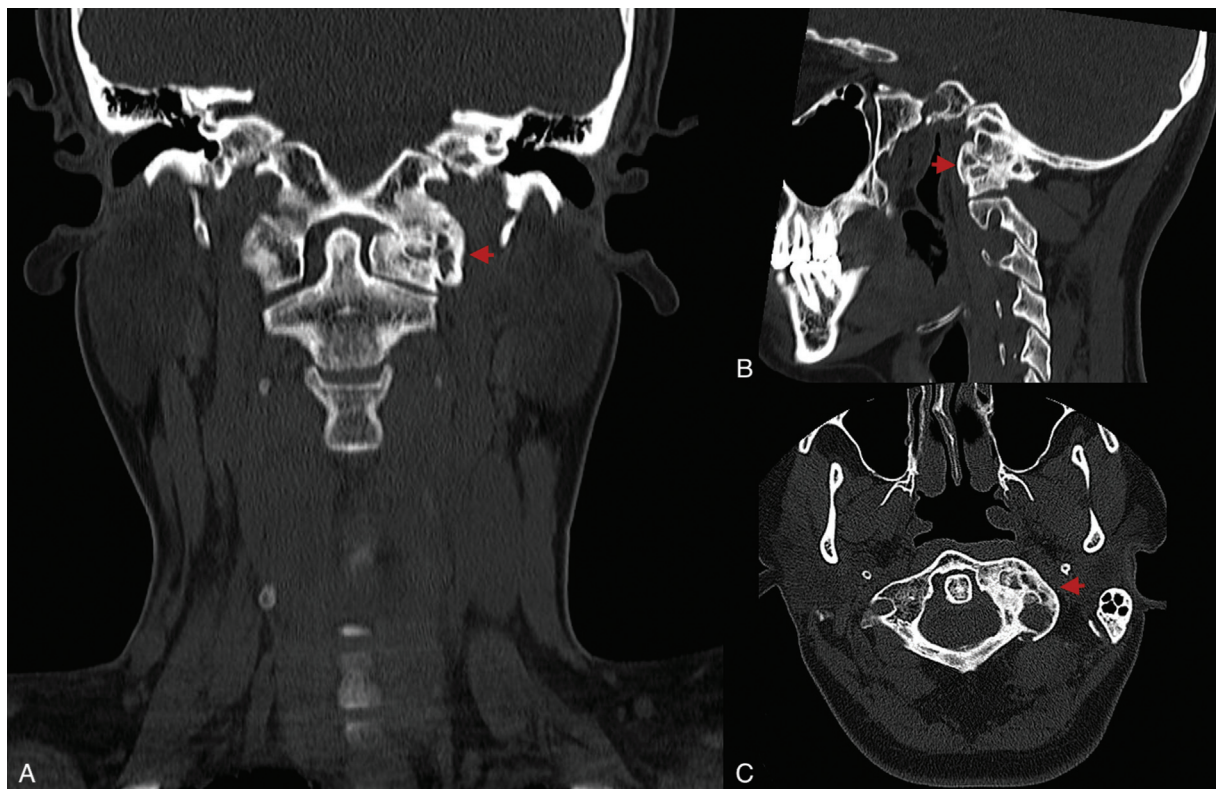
Cervical computed tomography scan with no contrast twelve months into the treatment. Coronal (A), sagittal (B), and axial (C) sections showing significant lesion corticalization.
